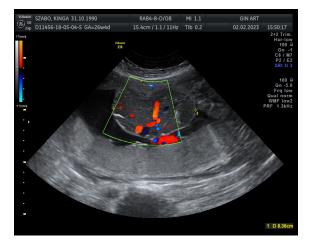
Doppler imaging highlights a relatively rich vascularity.
